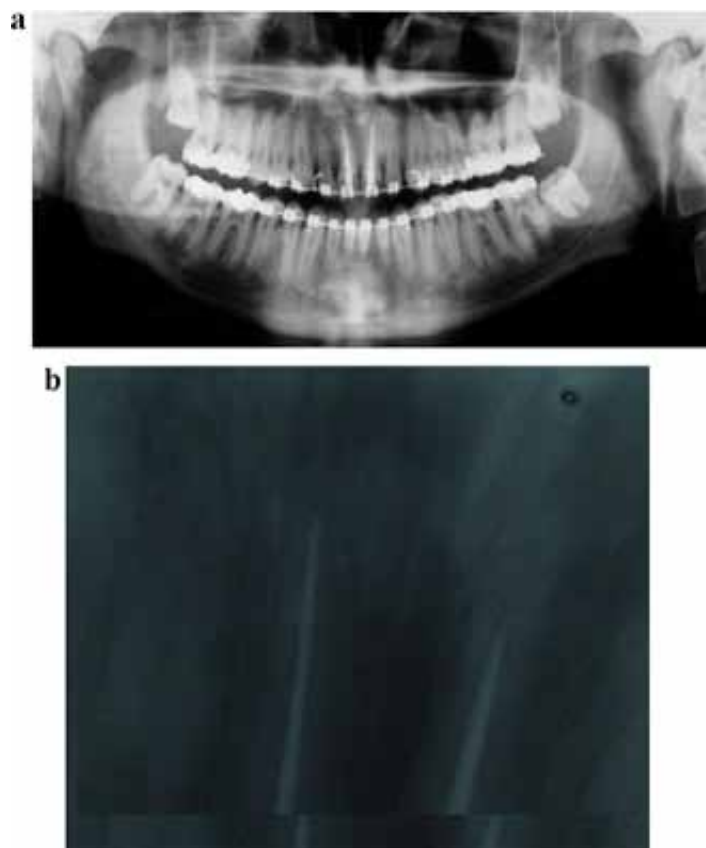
Two years post-treatment panoramic and intraoral radiograph showing the complete healing of the periapical lesions and healthy root apexes.
